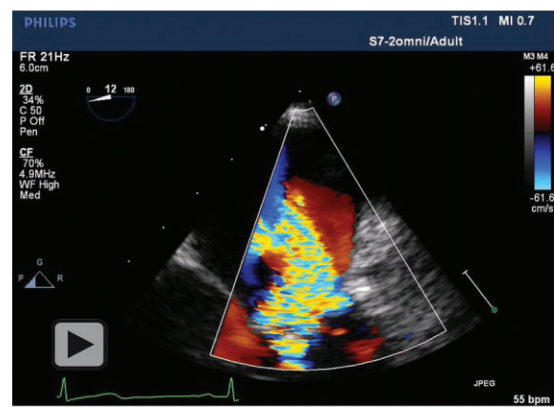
Transoesophageal echocardiography at J10 revealed a 13 mm vegetation on the anterior leaflet of the mitral valve in a commissural view 60° with a 3D reconstruction showing the insertion on the A1 segment near the anterior commissure (upper left and right panels, vegetation indicated by the arrow). Colour Doppler rayon PISA 14 mm in favour of severe mitral insufficiency (lower left and right panels). Anatomical landmarks: AMV, anterior mitral valve; LA, left atrium; LV, left ventricle; PMV, posterior mitral valve.
